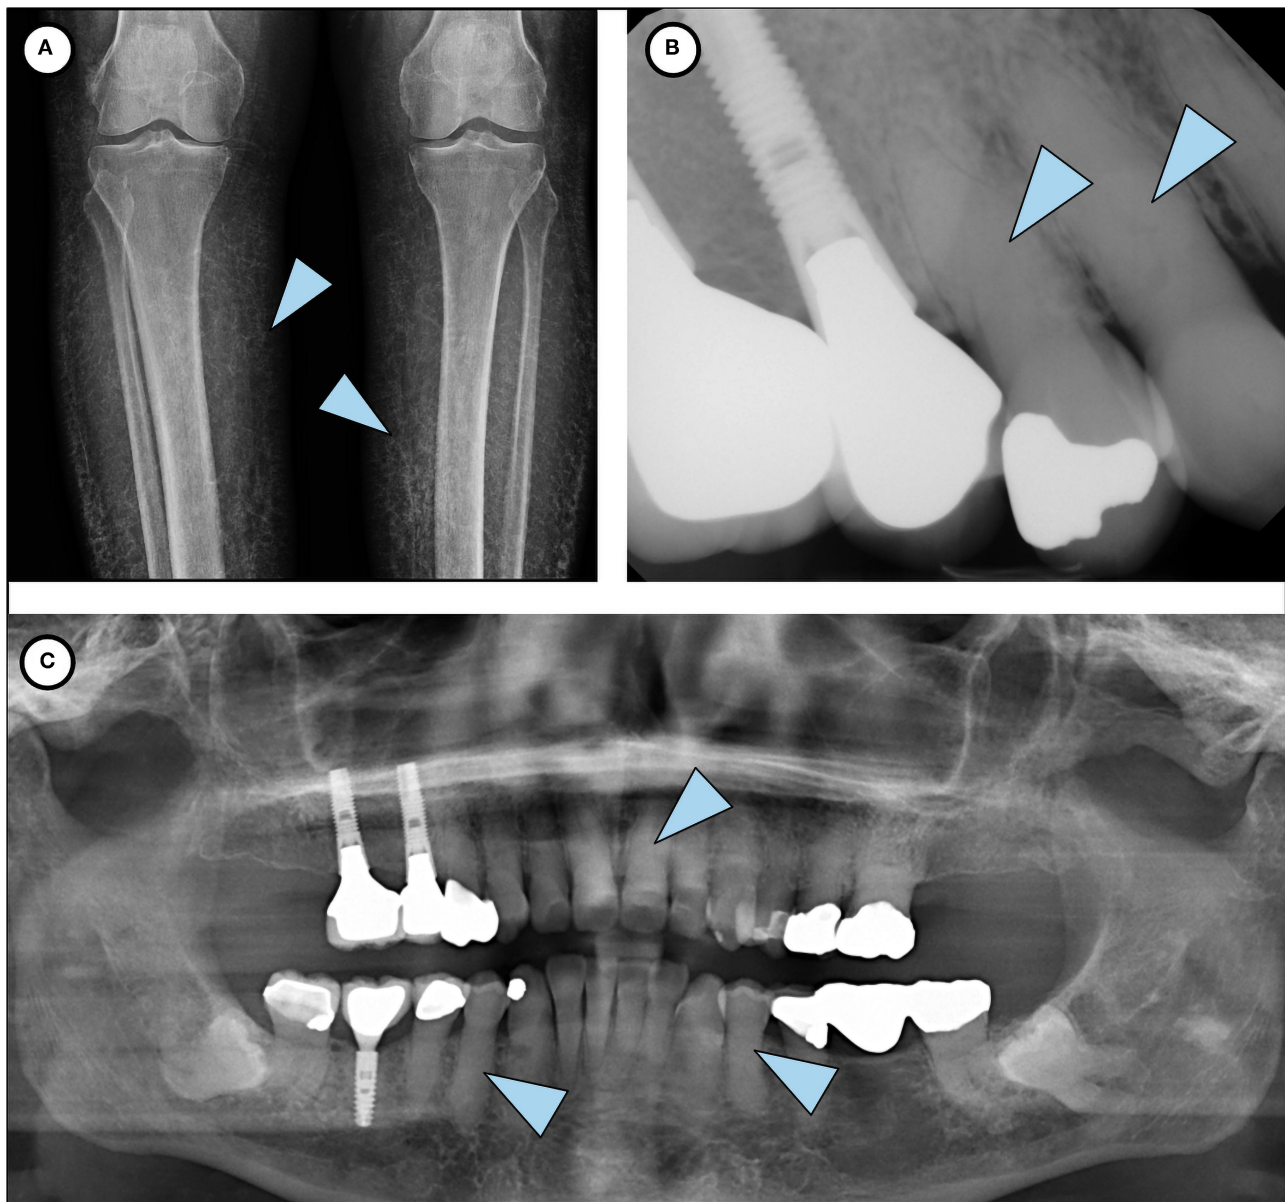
Phenotypic features of HFTC. (A) Lower limb radiograph shows subcutaneous calcification of her legs, an unusual and rare finding seen in older patients with HFTC. (B) Periapical radiograph of teeth # 5 and 6 shows complete pulp obliteration and thistle-shaped roots. (C) Panoramic radiograph shows short bulbous root with complete pulp obliteration in all teeth.
